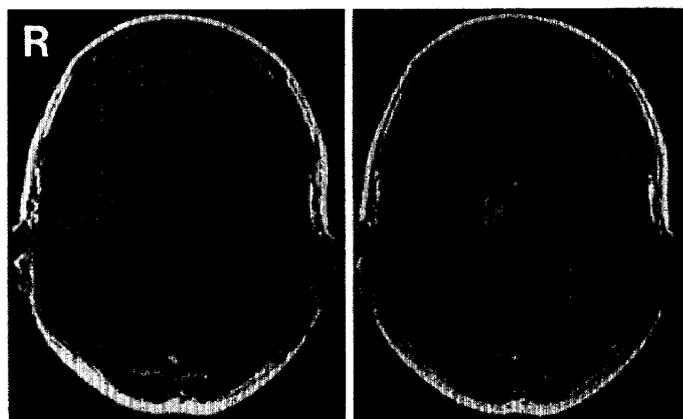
T₁-weighted magnetic resonance images, without (left) and with (right) gadolinium-diethylenetriaminepenta-acetic acid, revealing a homogeneously enhanced lesion in the right petrous apex, extending to the cavernous sinus.
